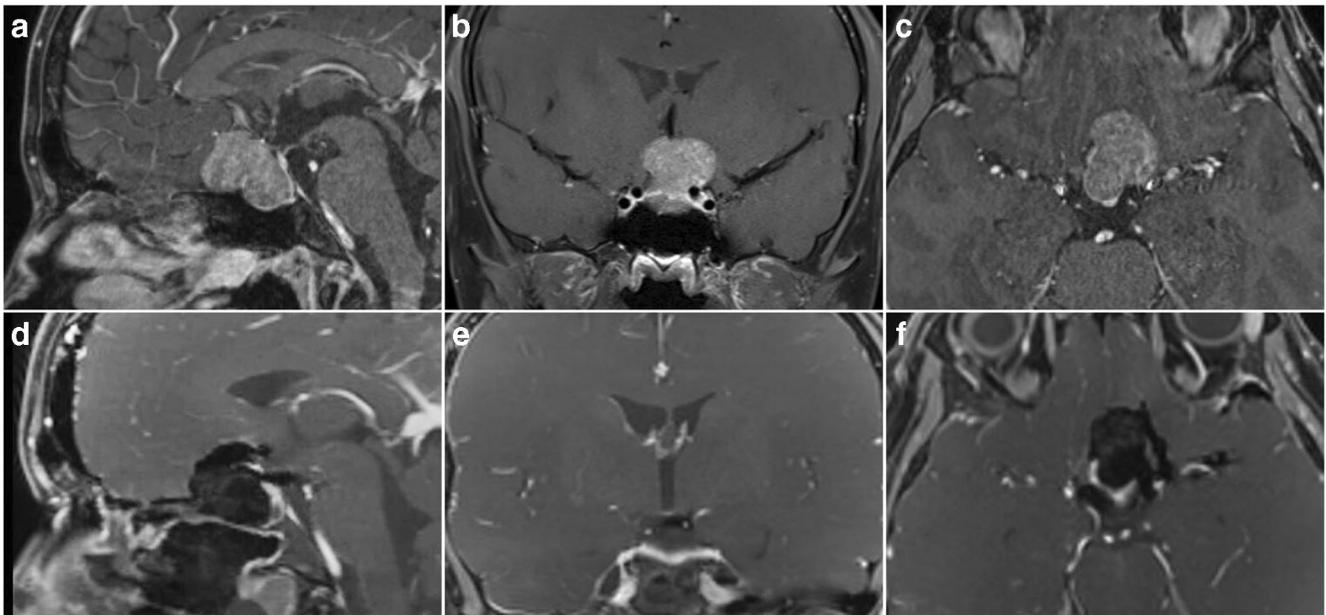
A case of a 17-year-old male who presented with a progressive vision loss and a TSHoma that was managed surgically via an expanded endoscopic endonasal approach. Images demonstrated here are pre-operative and post-operative MRI scans. a Sagittal, b coronal, and c axial T1-weighted MRI images with contrast demonstrating a macroadenoma
